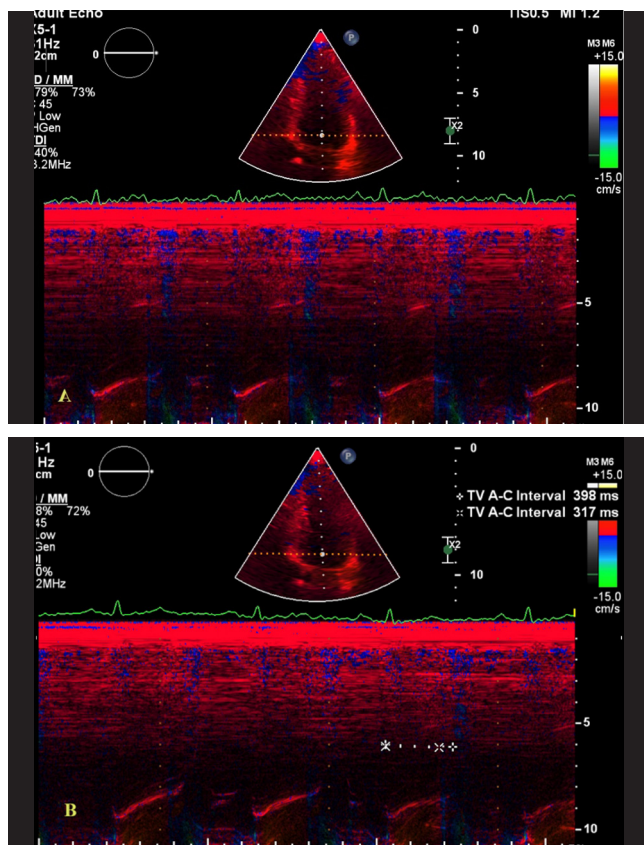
A) Color-coded AMM in the apical 4-chamber view in the basal segments of the septal and lateral walls. Notably, the maximum excursion of the walls occurs concomitantly with the change of color from red to blue at the end of the T wave in the lateral wall and the peak of the T wave in the septal wall.
